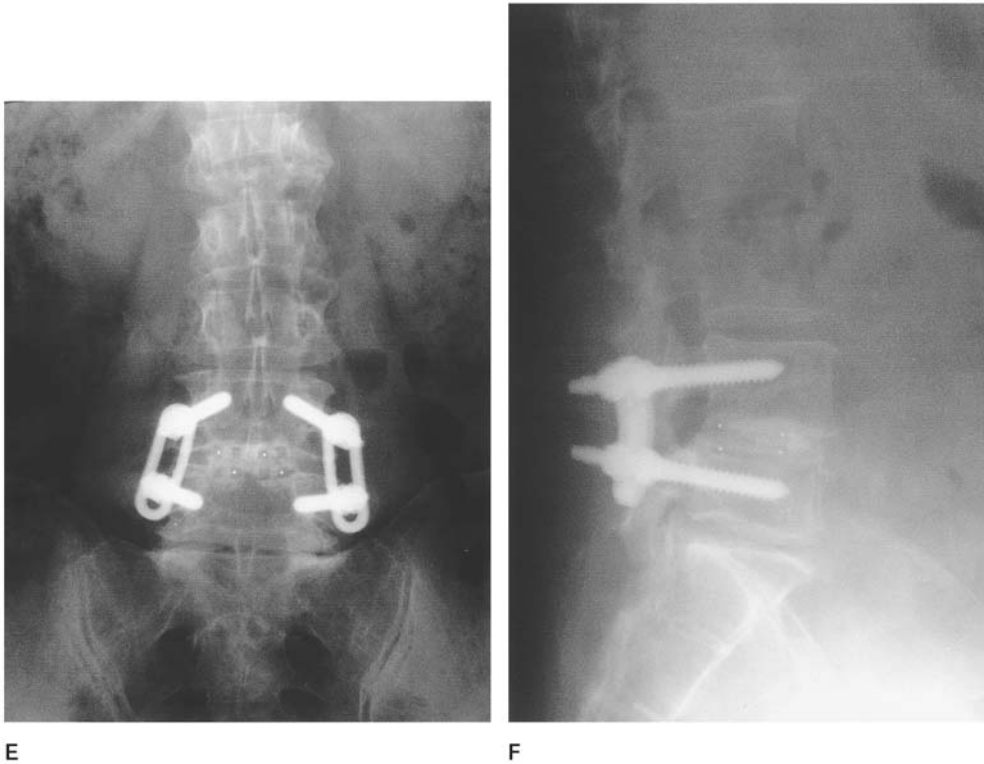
Continued. (E) A-P x-ray film at 13 months after surgery; (F) lateral x-ray film at 13 months after surgery.
